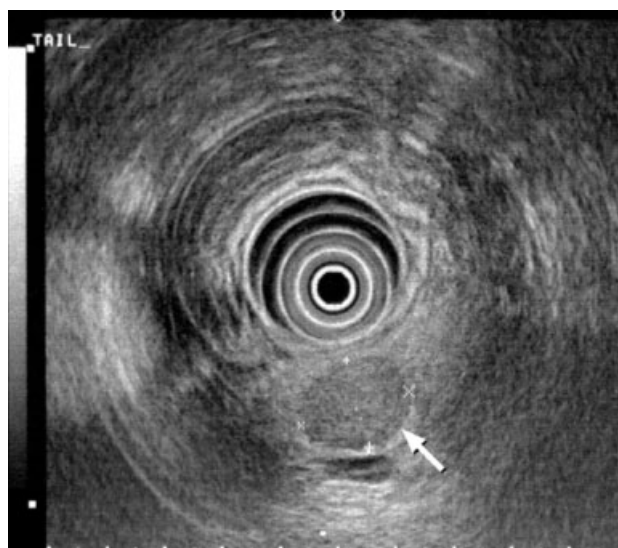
A 1.4 × 2.8-cm pancreatic endocrine tumour of the pancreatic tail (arrow) demonstrated on endoscopic ultrasonography in a 28-year-old patient with hyperparathyroidism and a serum gastrin level of 118 pg/ml
